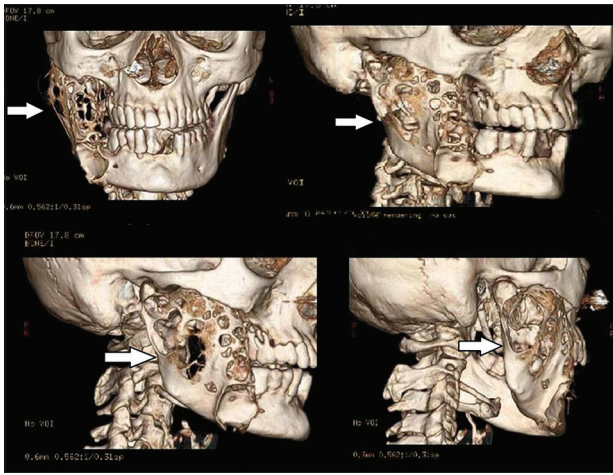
3D CT view showing multiple locules over the right side of the mandible causing expansion and thinning of the cortical plates extending from body of the mandible to involve the entire ramus
